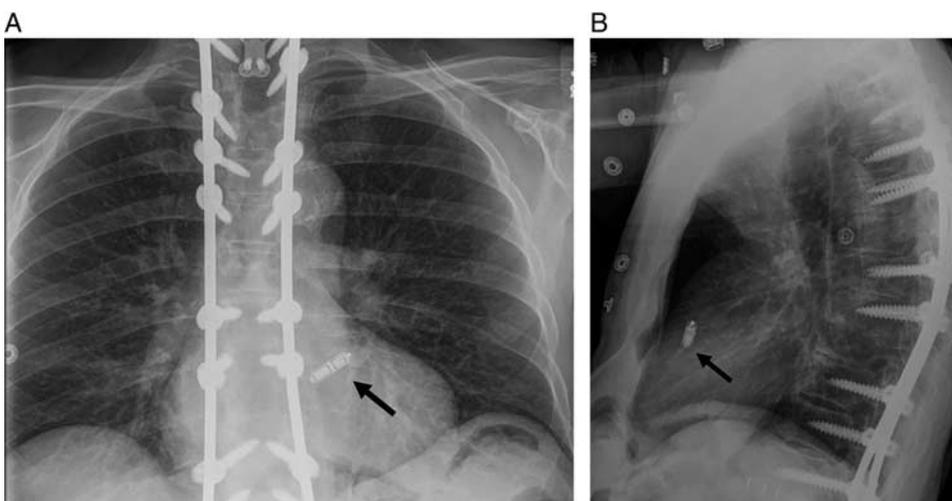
Micra intracardiac pacemaker: frontal (A) and lateral (B) radiograph of Micra intracardiac pacemaker, which appears similar to a USB drive. The patient also has thoracolumbar posterior spinal fusion hardware. Attention must be focused on positioning during image acquisition to visualize the device on both views with adequate patient rotation.
